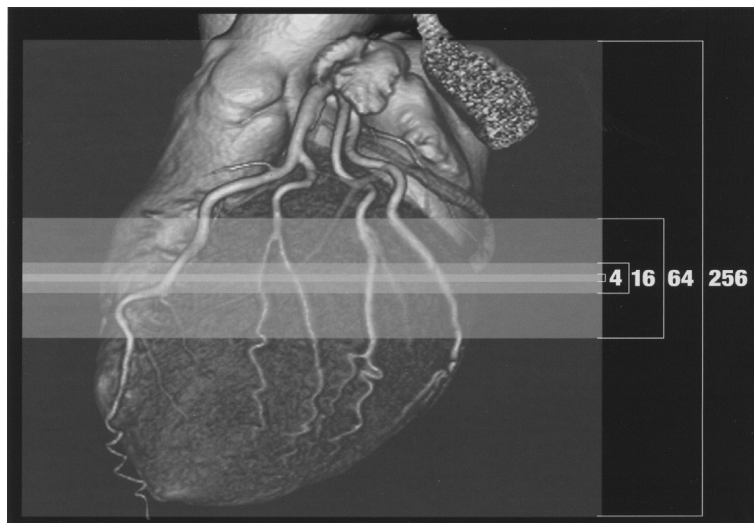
A 3D volume rendered image of the heart from data acquired by a 64-slice CT scanner. Note that a 256-slice CT scanner would be able to scan the entire heart in one single rotation (courtesy of Toshiba Medical Systems).
